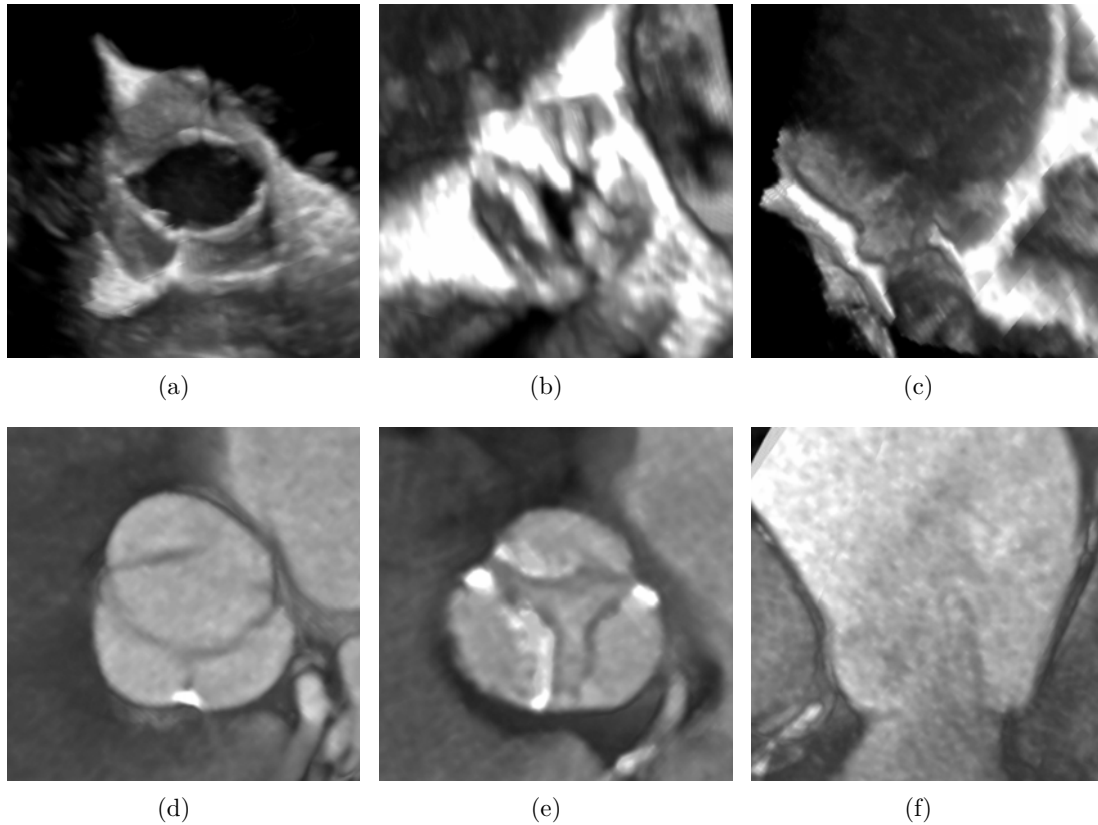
Examples of aortic valve disease: bicuspid aortic valve from TEE (a) and CT (d), stenotic aortic valve with calcification from TEE (b) and CT (e), and dilated aortic root with valve regurgitation from TEE (c) and CT (f).
